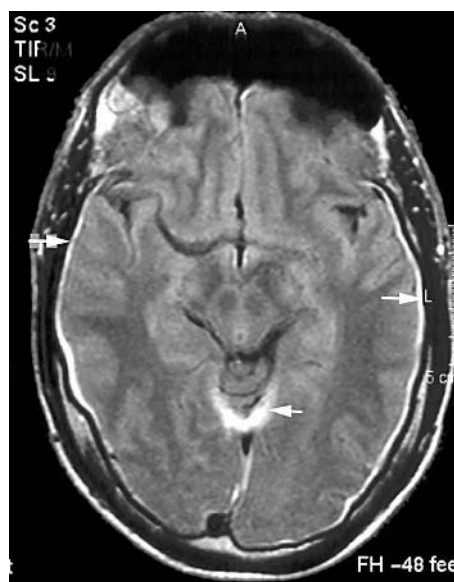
Cranial MRI (axial FLAIR sequence) showing bilateral, small subdural haematomata (arrows) and subdural haemorrhage on the tentorium.
